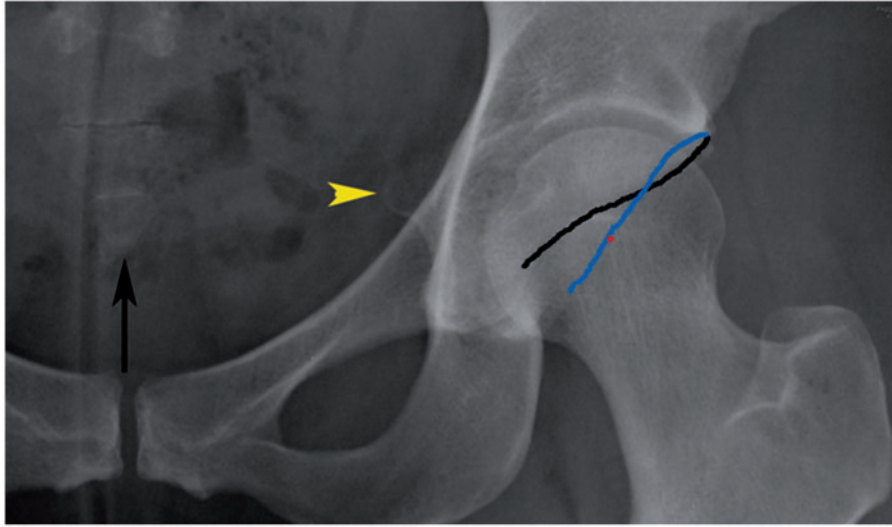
Detail of an AP pelvis radiograph with representative findings of focal pincer subtype with cephalad crossover sign, CEA of 33 degrees and ischial spine sign (yellow arrow). Note the posterior wall (blue line) passing through center of femoral head (red dot) and the anterior wall (black line) lateral to the posterior wall proximal to the crossover point. The black arrow shows alignment of coccyx with pubic symphysis. Note that although floor of acetabular fossa meets ilioischial line which some would consider coxa profunda, this study classifies this hip as focal acetabular overcoverage.
